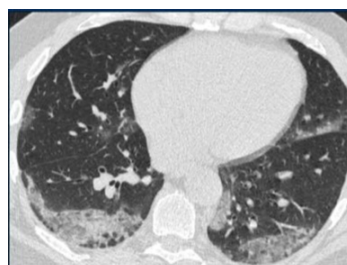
Axial and Sagittal CT images shows subpleural and peri-bronchovascular ground glass opacities and consolidation.
